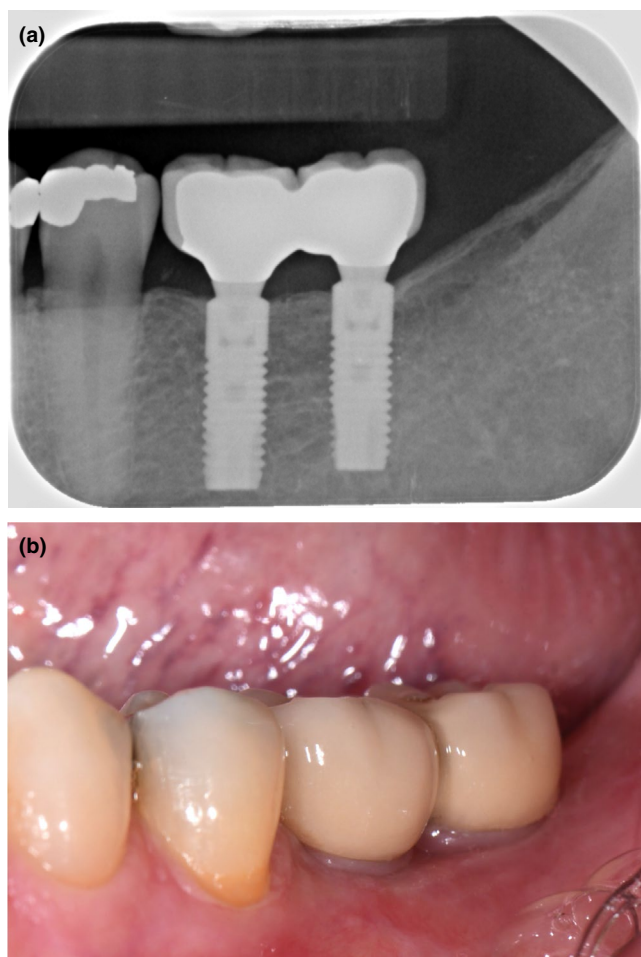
Five-year follow-up radiograph (a) and clinical photograph (b) of patient with two 11-mm implants (case images; courtesy of Dr. Stephen Chen)
